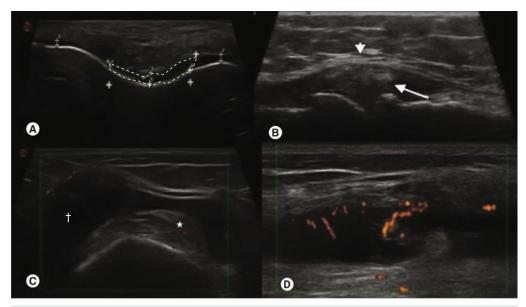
Spectrum of soft tissue and structural joint damage in knee osteoarthritis. (A) Asymmetric narrowing of the cartilage layer (marked by the dotted line). (B) Meniscal protrusion (arrow) with displacement of medial collateral ligament (arrowhead). (C) Short axis view of the suprapatellar pouch showing synovitis (synovial hypertrophy [\star] and effusion [†]). (D) Power Doppler image of the suprapatellar pouch demonstrating synovial hypervascularity.
